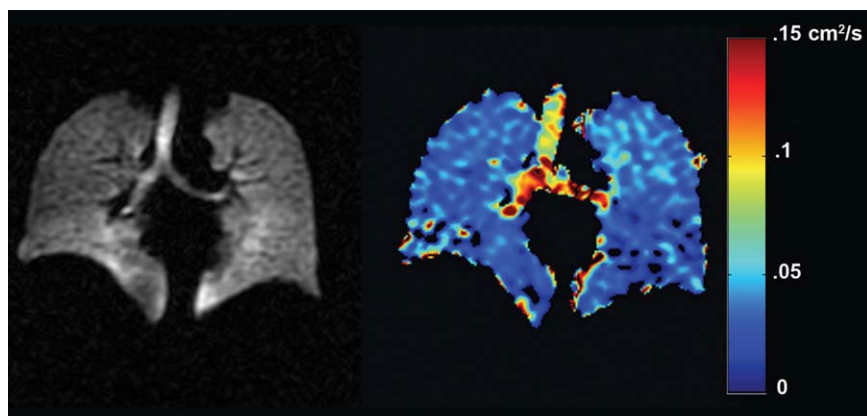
Spin density and ADC map using single inhalation of HP Xe-129 MRI. The ADC values are much lower due to high density of Xe-129, which may be advantageous in certain diseases for short range diffusion measures. Image courtesy Dr. Bastiaan Driehuys and GE Healthcare.
